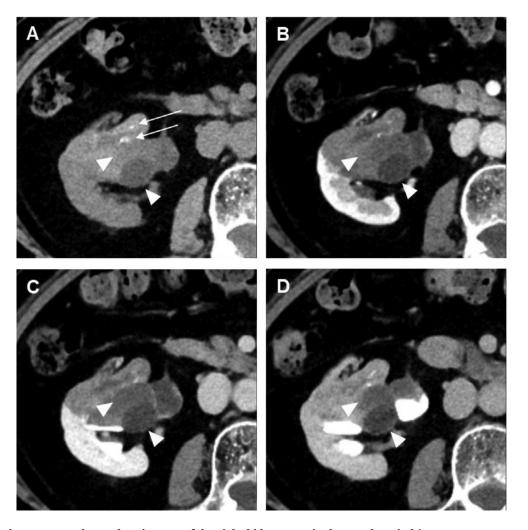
Dynamic contrast-enhanced CT images of the right kidney acquired at our hospital (A: precontrast, B: arterial phase, C: equilibrium phase, D: excretory phase). A lobulated mass in the right kidney protrudes into the renal sinus. The mass is heterogeneous and contains a solid component that shows gradual enhancement on dynamic CT. Several small calcifications are noted within the mass (arrows), in addition to some cystic components (arrowheads).
